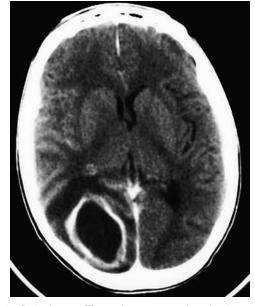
Brain abscess. CT scan demonstrates a low-density mass lesion with an enhancing rim and surrounding edema in an immunosuppressed patient with an *Aspergillus* abscess. Bacterial abscesses and neoplasms can present a similar CT appearance. (*Courtesy Department of Neuroradiology, University Health Center of Pittsburgh, Pittsburgh, Pa.*)
